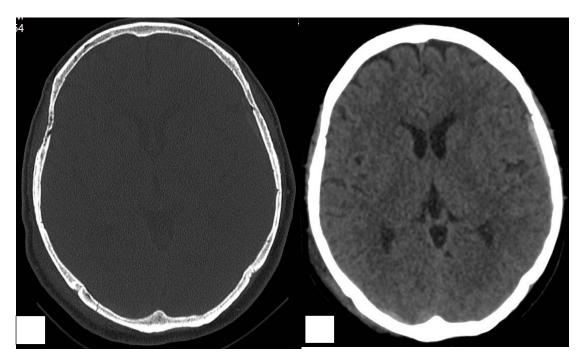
Axial plain CT brain of a 60-year old patient showing (a) bone window; linear fracture at the right occipital and (b) subdural window; small extradural haemorrhage at the right occipital and subdural haemorrhage at the left parietal region.
